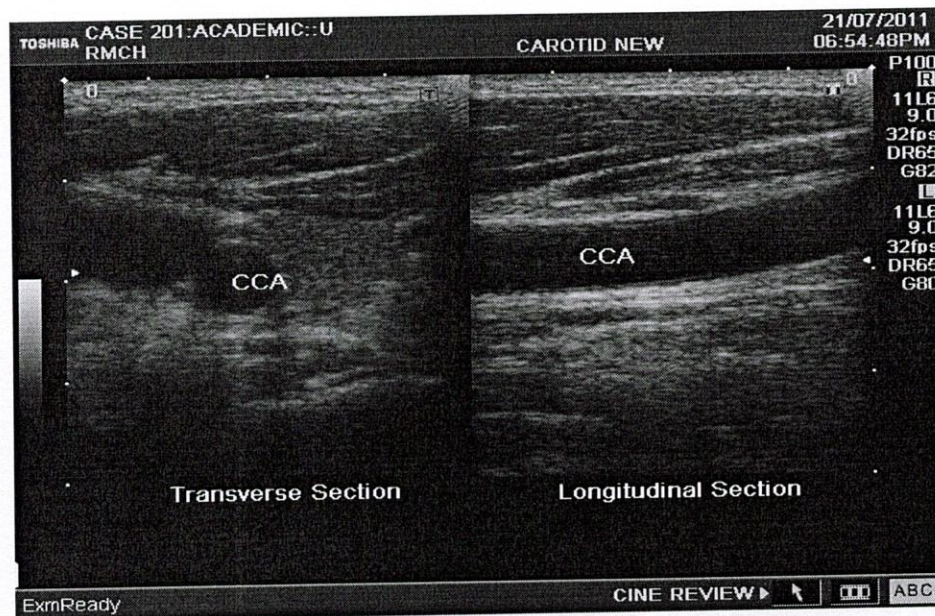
Linear Transducer for vascular ultrasound scans
